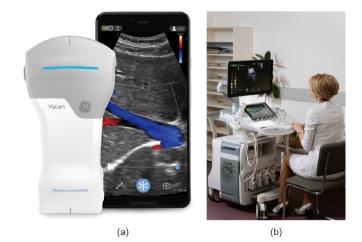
(a) Able to scan continuously for 50 min on a 90 min charge, the Vscan Air, GE Heathcare's latest model handheld ultrasound system pairs wirelessly with a smartphone or tablet. The curvilinear probe on the top of the device can scan (2–5 MHz) to a depth of 24 cm, while the linear probe at its base is for shallower scanning (3–12 MHz), up to 8 cm. The probe measures 131 mm × 64 mm × 31 mm, and weighs about 205 g. (b) For size/portability comparison, the high-end, cartbased system is a GE Healthcare Voluson ultrasound unit. Credit: (a) GE Healthcare, with permission; (b) public domain.
